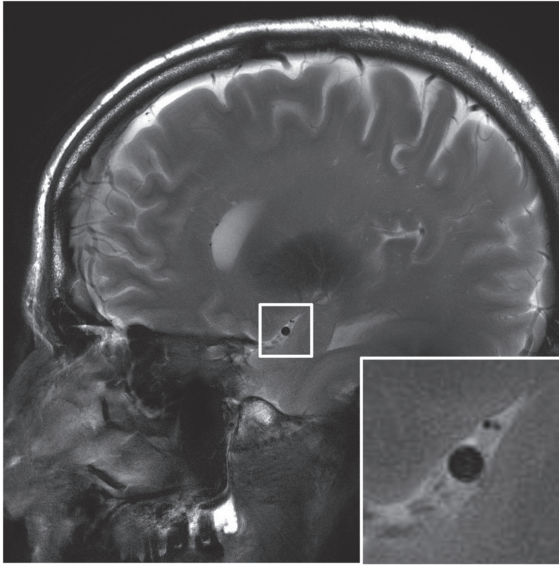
Example of a high resolution cardiac triggered MRI scan of the MCA; based on the black blood principle. The white box indicates the zoomed area showing the lumen of the MCA.
